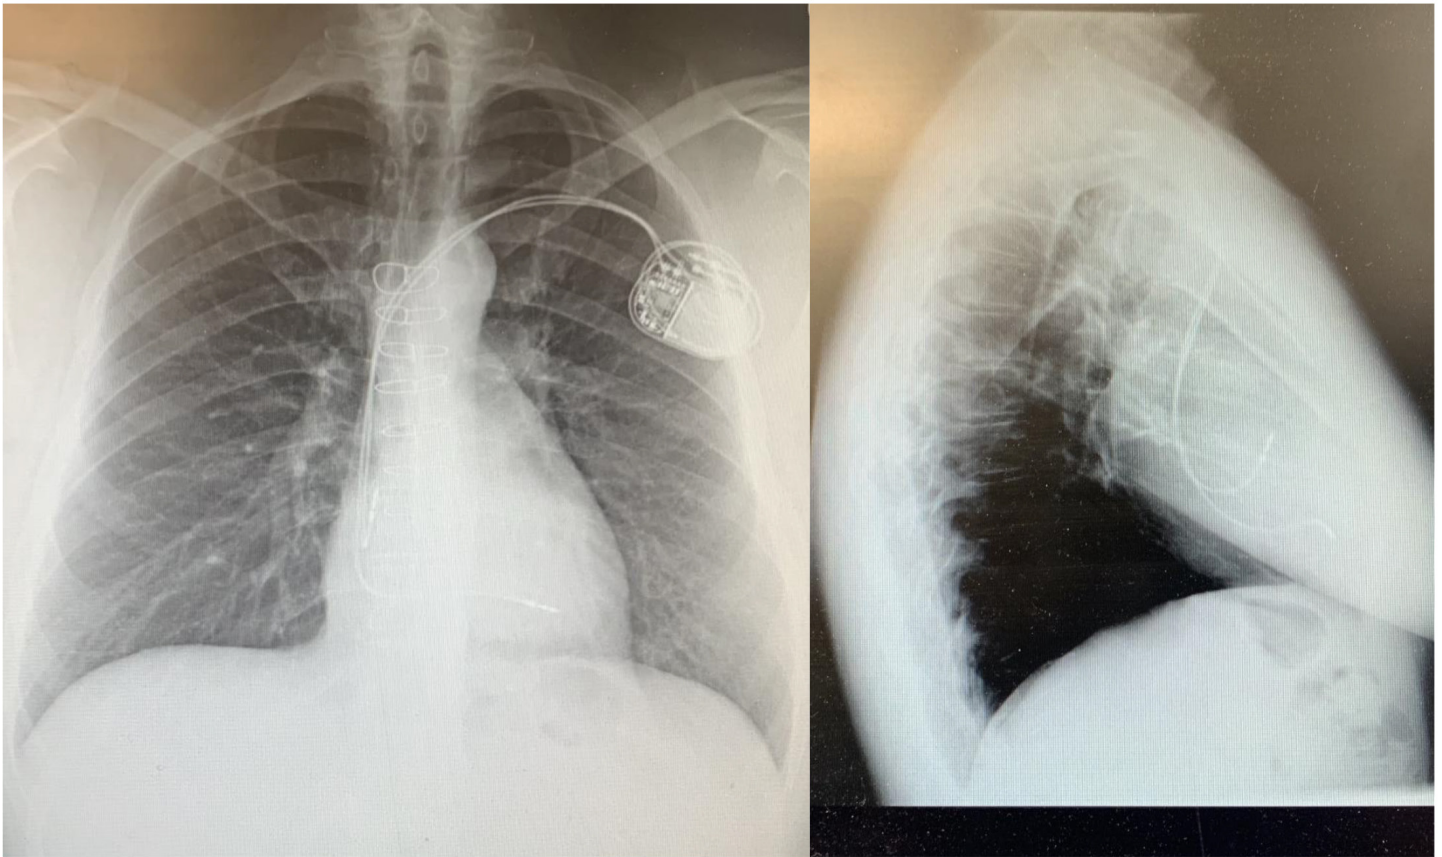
Chest X-ray of the initial pacemaker system with apparent RV apical lead placement.
